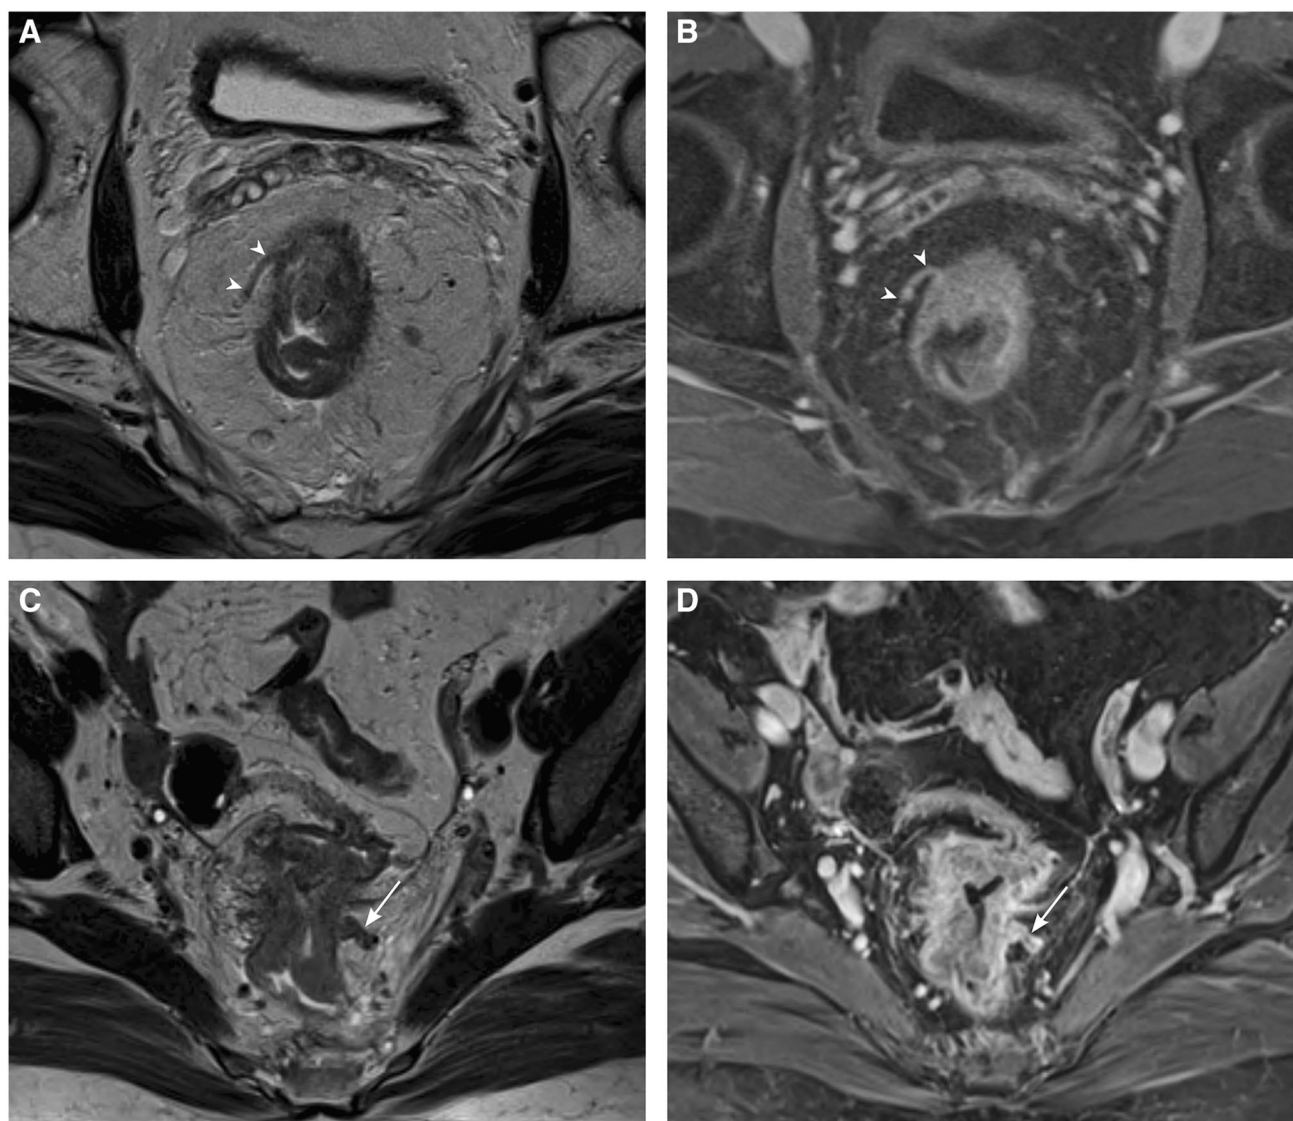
Added value of contrast-enhanced MRI to T2WI for EMVI scoring. A and B 39-year-old male with slightly prominent vein (score 2) depicted in axial T2-weighted image which after contrast administration demonstrates normal enhancement and reclassified as score 1
